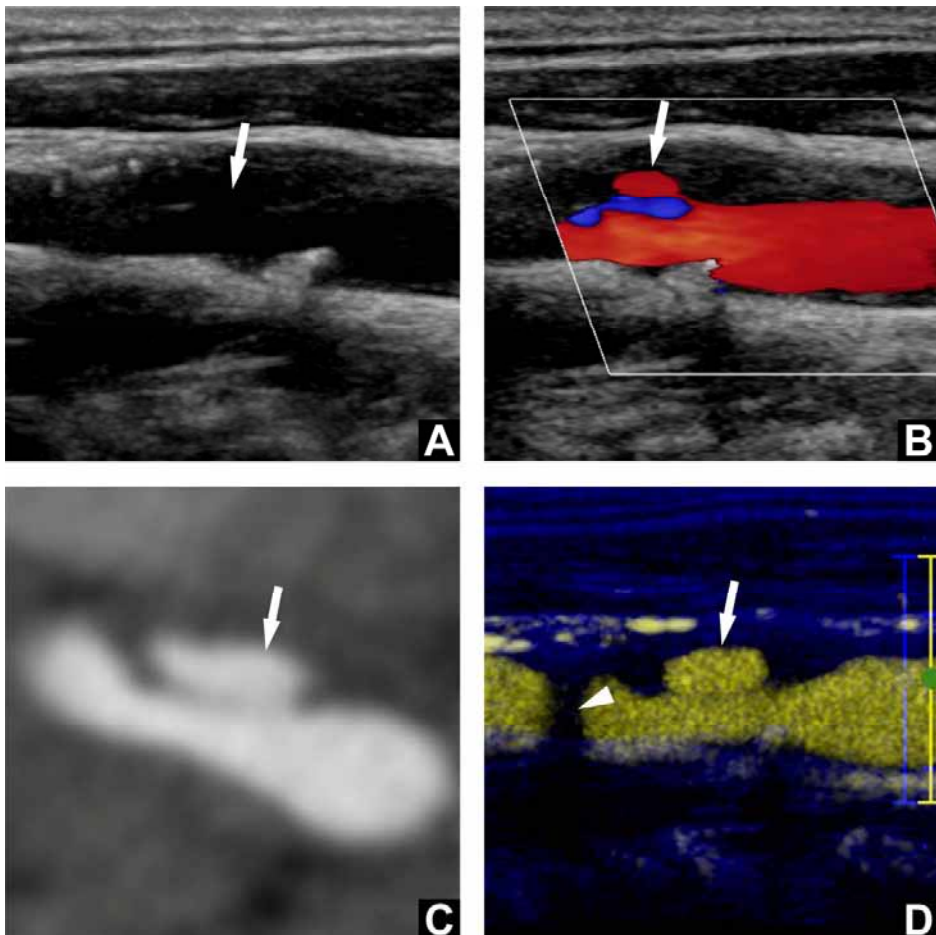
Longitudinal images of carotid plaque classified as ulcerated using CDUS, CEUS, and CTA. Longitudinal B-mode ultrasound (A), CDUS (B), CTA (C), and CEUS (D). A hypoechoic plaque with ulceration is present in carotid bulb (arrows). A small calcification causes shadowing that hindered visualization of a small part of the plaque surface (D, arrowhead).
